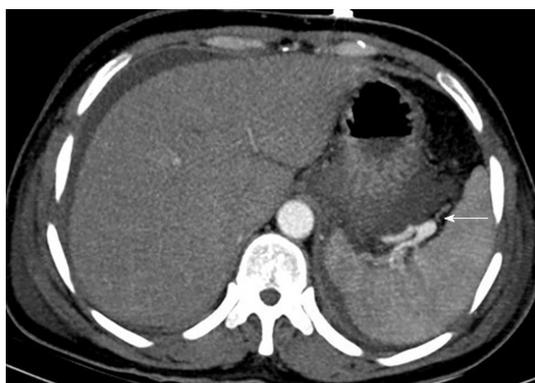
Pseudoaneurysm. Axial contrast-enhanced CT image in a 42-year-old female patient with severe acute biliary pancreatitis shows a pseudoaneurysm of the splenic artery (arrow), and the patient was discharged without gastrointestinal hemorrhage or intra-abdominal hemorrhage.
